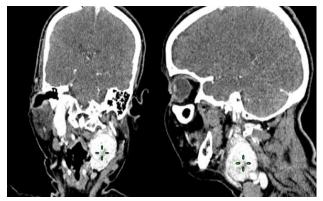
Two CT scans of the patient. Coronal to left and axial to a new carotid paraganglioma left (green sign) raised after injection
